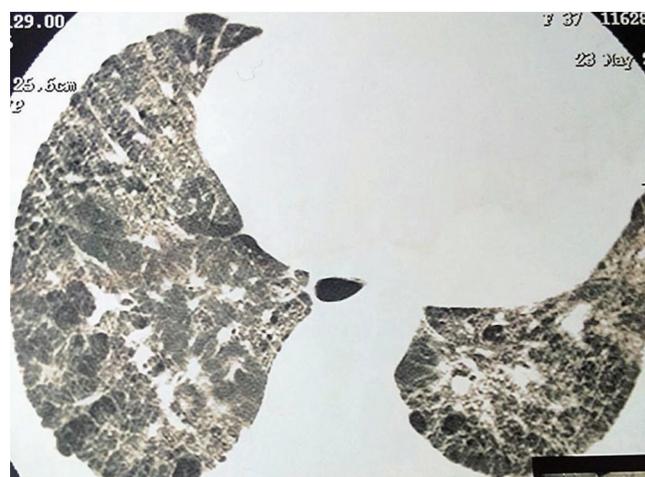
HRCT image of lung showing interlobular septal thickening and bronchiolectasis
